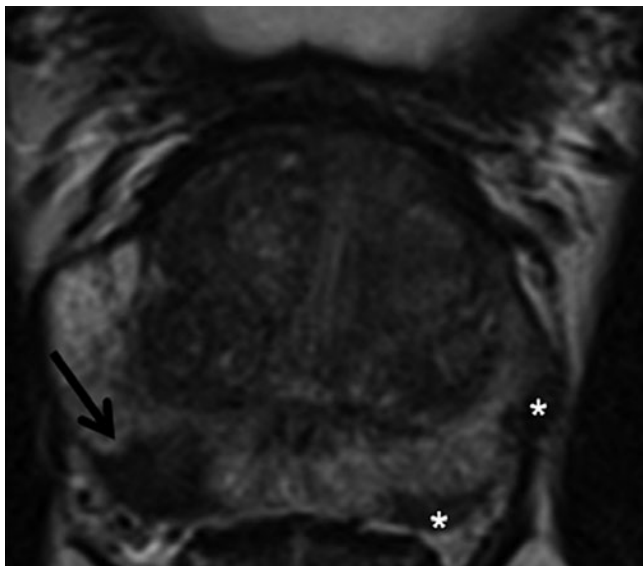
Prostate cancer of the peripheral zone: Axial T2-weighted turbo-spin-echo (TSE) sequence with a hypointense lesion on the right side in the peripheral zone (arrow). After targeted biopsy under magnetic resonance imaging (MRI) guidance, an acinar prostate adenocarcinoma with a Gleason score of 3 + 4 = 7 was detected. The additional, smaller foci on the left side of the peripheral zone should also be mentioned (*)
